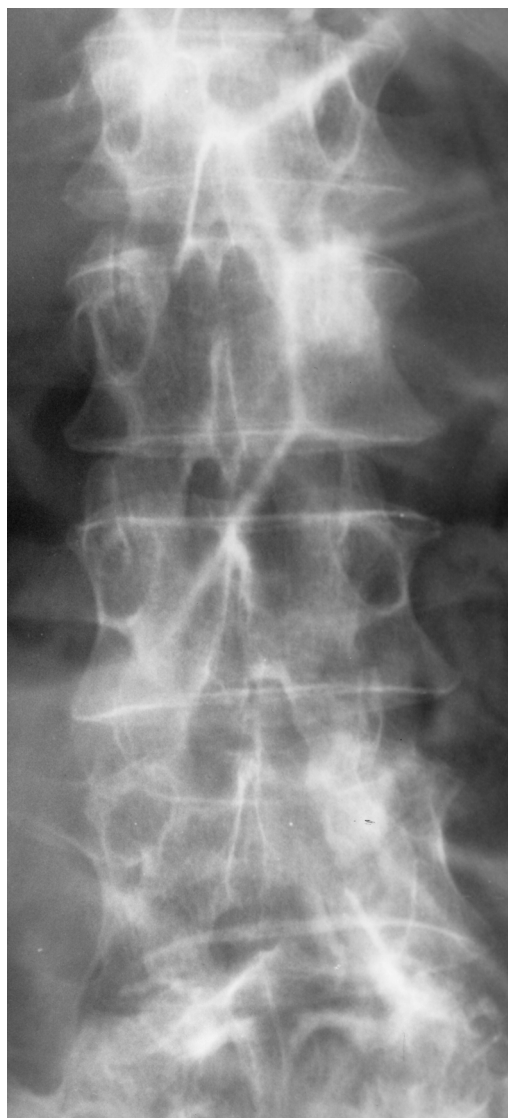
Common bone X-ray of osteosclerotic metastasis (pedicles) from prostatic cancer.
